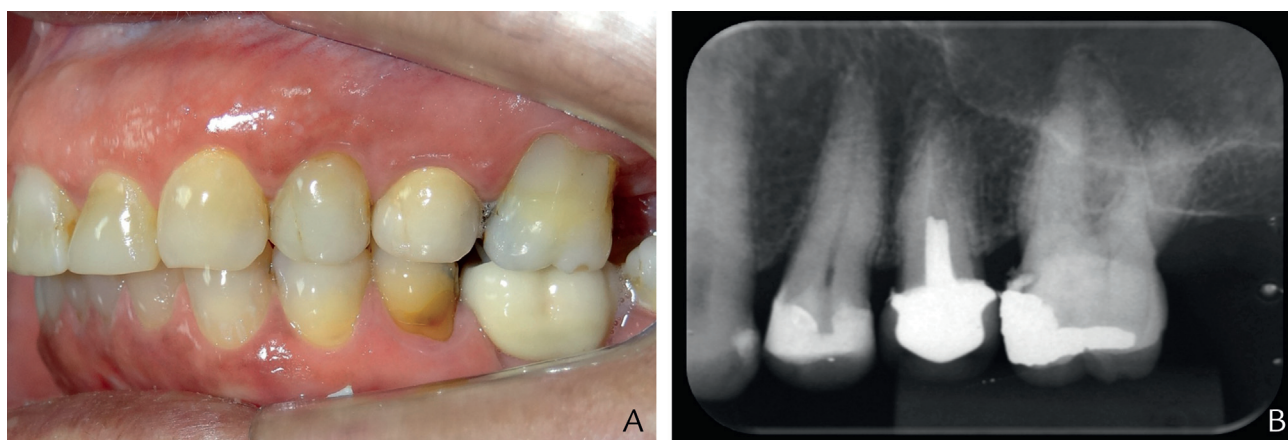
A, At 5 years' follow-up. B, Periapical radiograph.
